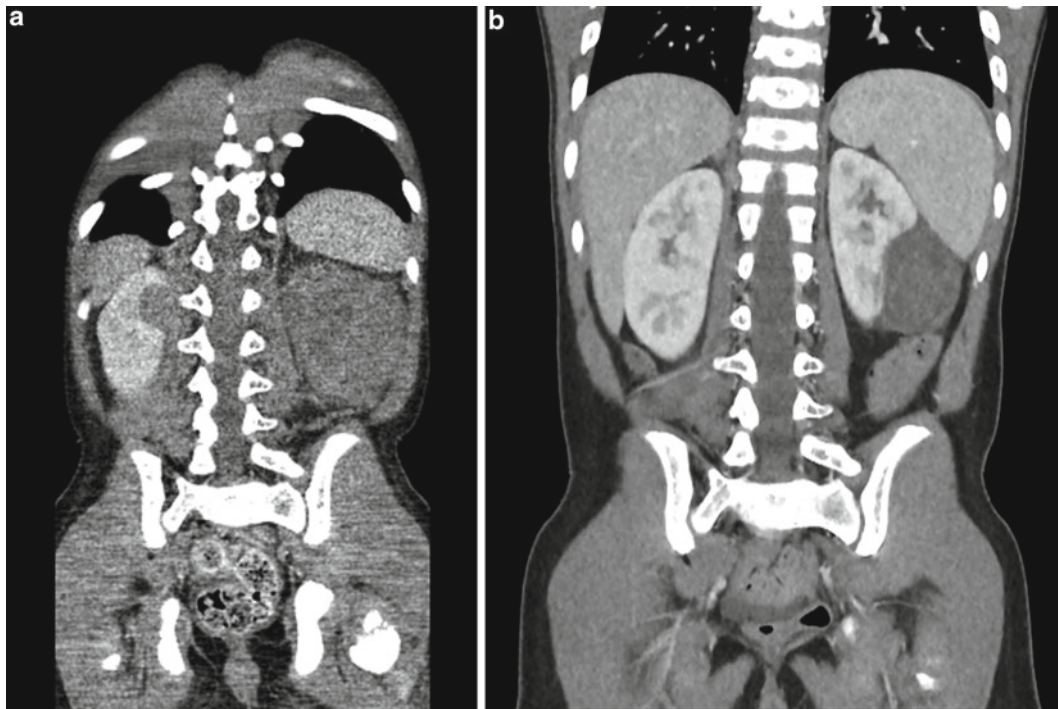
(a) A CT scan of child at presentation with bilateral Wilms tumor showing a very large right-sided tumor and a smaller left-sided one. (b) The small child after four rounds of chemotherapy showing excellent response to the chemotherapy
